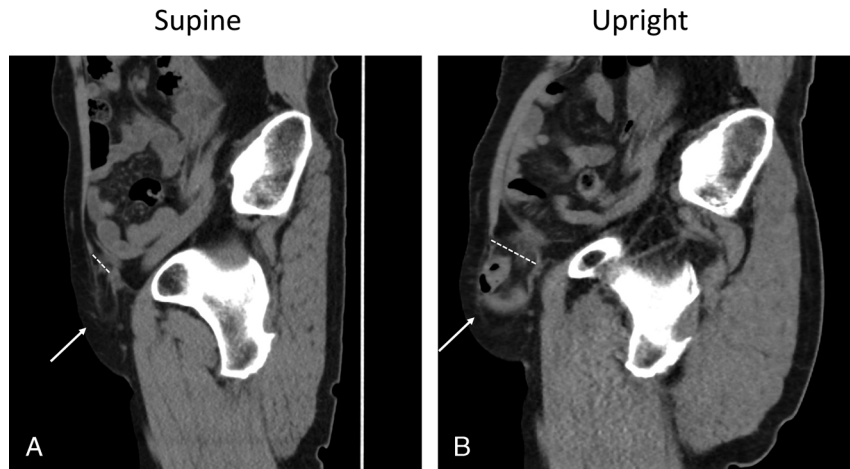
A case of inguinal hernia. Conventional supine CT shows mild left inguinal hernia (A, dot line, size of hernia orifice is 16.0 mm), and the hernia content is fat tissue only (A, arrow). Upright CT shows more apparent inguinal hernia (B, dot line, size of hernia orifice is 32.1 mm), and the hernia contents include small intestine and fat tissue (B, arrow).
